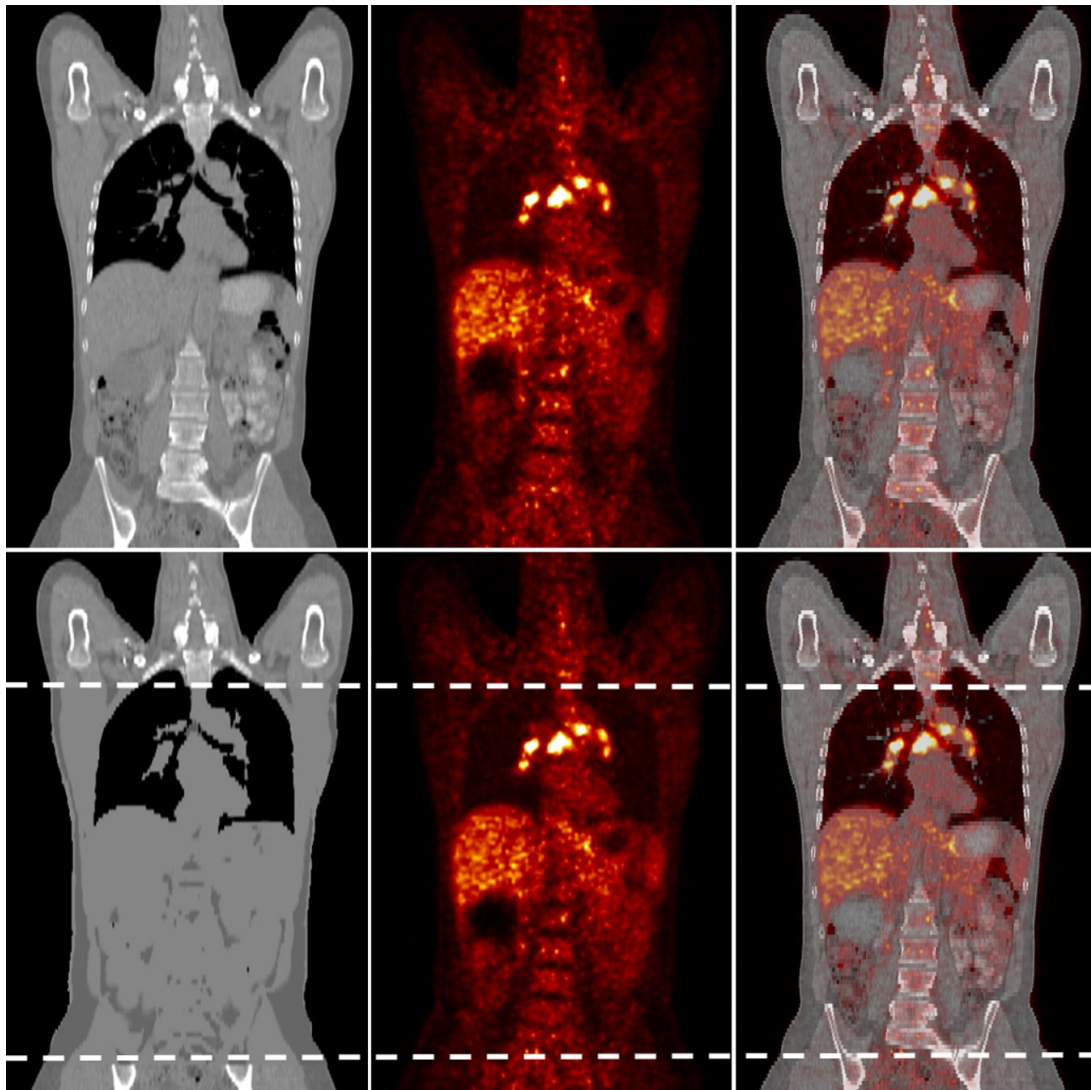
Attenuation map (left), PET images (center), and fused PET/CT images (right) of patient with multiple ^{18}F -FDG-avid mediastinal and hilar lymph node metastases. On the top, original CT-based attenuation map and PET image reconstructed with this map. On the bottom, MRI-based attenuation map for region indicated by dashed lines and PET image reconstructed with this map. Use of MRI-based attenuation map resulted in average SUV change of 2.3% (range, -6%–+1%) for 6 lymph nodes metastases relative to results obtained with CT-based AC. Image reprinted by permission of the Society of Nuclear Medicine from [184].
